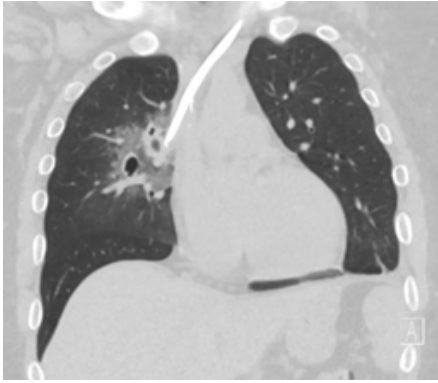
Coronal non-enhanced computed tomography scan of the chest shows erosion of the central line into the right upper lobe.
